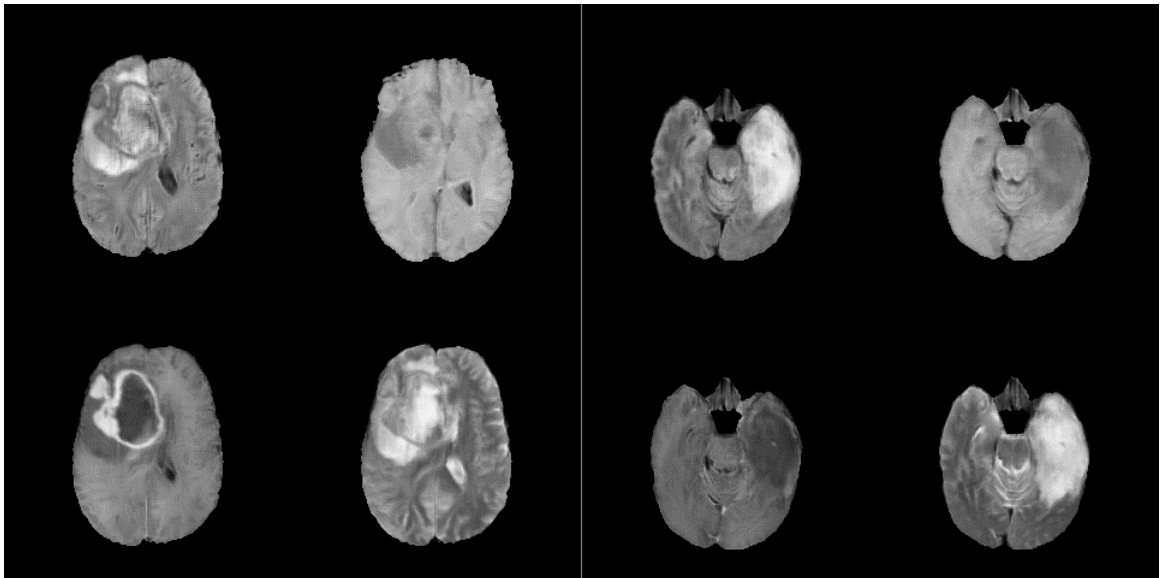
Two synthetic subject samples of all four MRI sequences, synthesized by the generator, from the axial view. Sequences: top left – flair, top right – t1, bottom left – t1ce, bottom right – t2. More samples available in Appendix 1 – Synthetic Samples (Figure 11).
